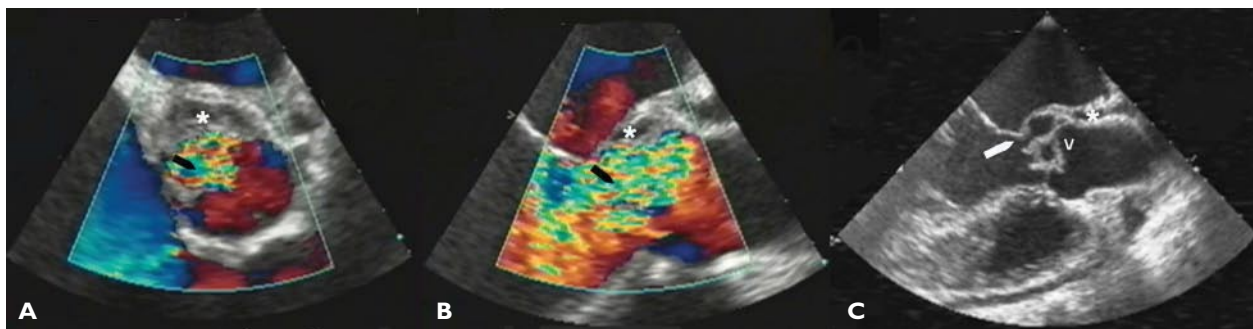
A transesophageal echocardiogram performed in the case patient, with (A) a short-axis view of the aortic valve showing a severe diastolic jet of aortic regurgitation (arrow) and a posteriorly located aortic root abscess (asterisk); (B) a long-axis view of the aortic root and left ventricular outflow, showing severe aortic regurgitation (arrow) with a portion of the aortic root abscess (asterisk) at the base of the noncoronary aortic cusp; and (C) a long-axis view of the aortic root and left ventricular outflow, showing an aortic root abscess (asterisk) and large vegetation (V) with perforation of the noncoronary cusp (arrow). The large abscess cavity partially elevates the noncoronary cusp from the underlying aortic wall.
